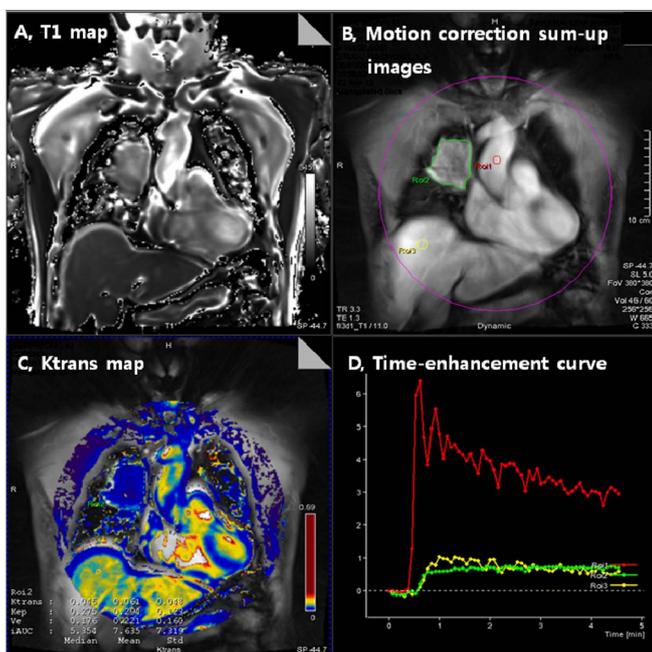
DCE-MRI of a patient with lung cancer
